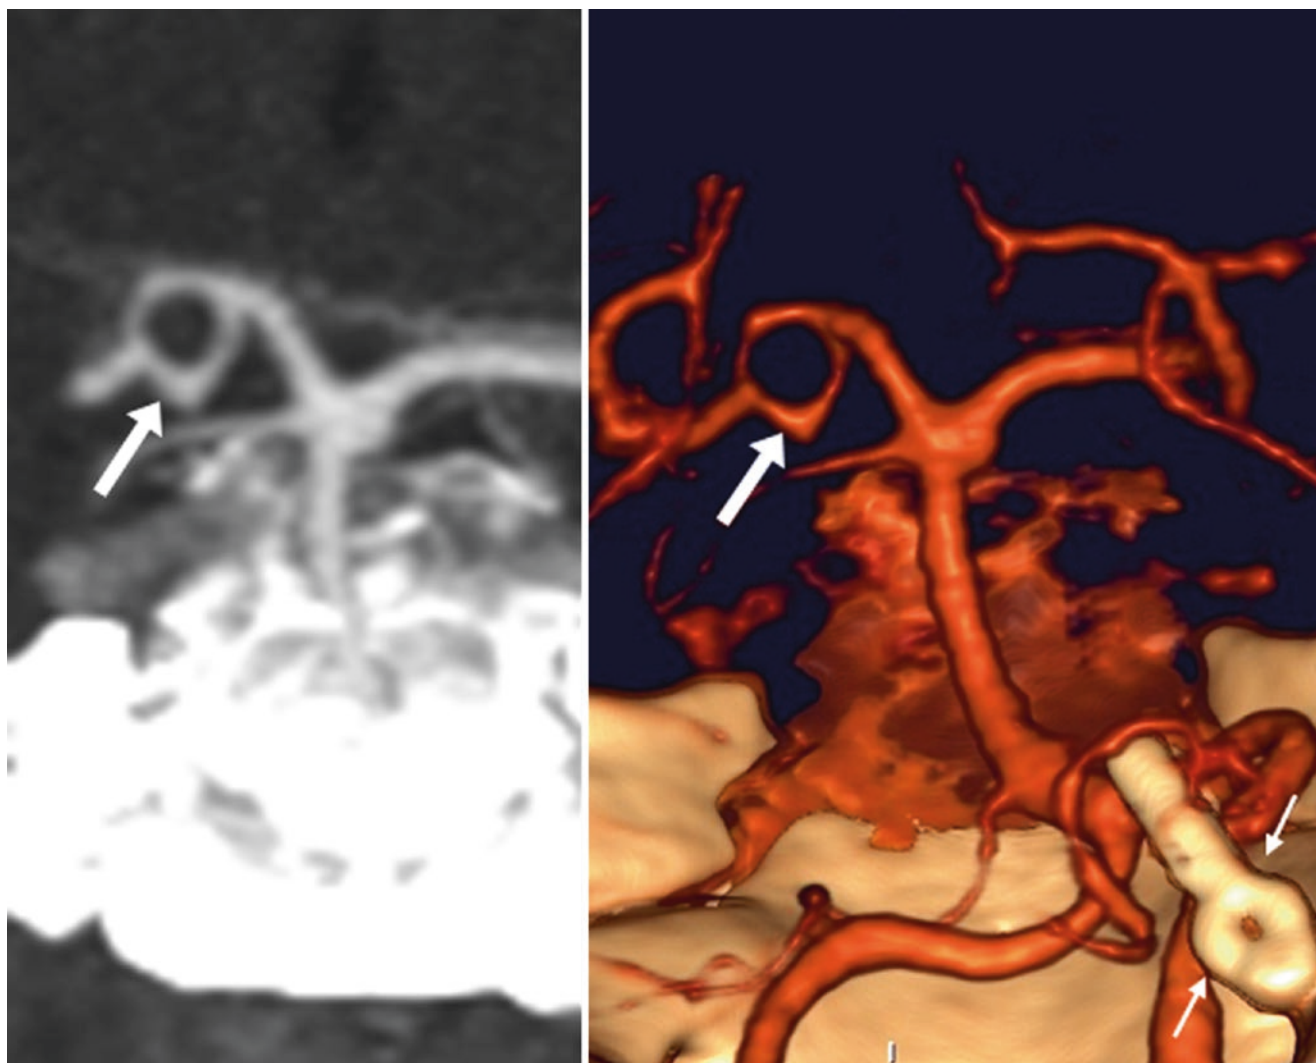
54-year-old with a left P1 segment fenestration (arrows) on a coronal MPR (left) and 3D VR CTA PA view (right). Note clips (thin arrows) previously placed for a left PICA aneurysm
